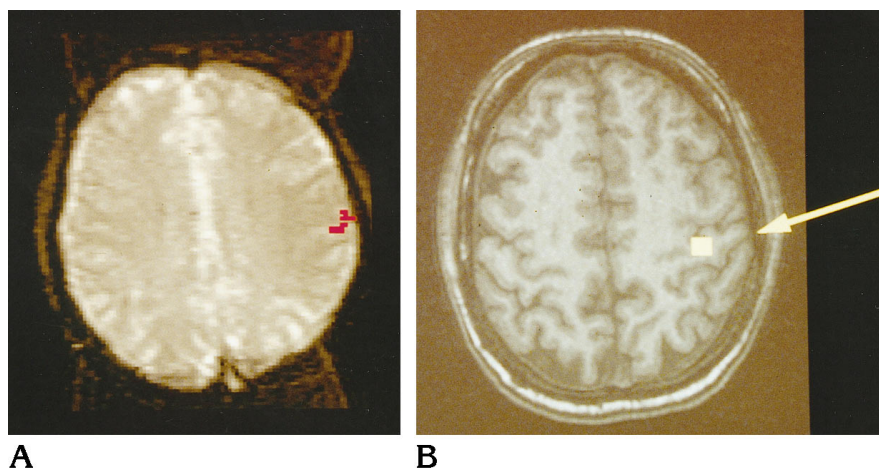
Right index finger stimulation: functional MR imaging (A) and magnetic source imaging (B). Pixels identified as activated with functional MR imaging are overlaid on an acquired gradient-echo echo-planar image (echo time, 60; flip angle, 90°; FOV, 40 × 20 cm; matrix, 128 × 128). Magnetic source imaging locations are overlaid on a spoiled gradient-echo MR image (35/5) (flip angle, 30°; section thickness, 1.5 mm).
